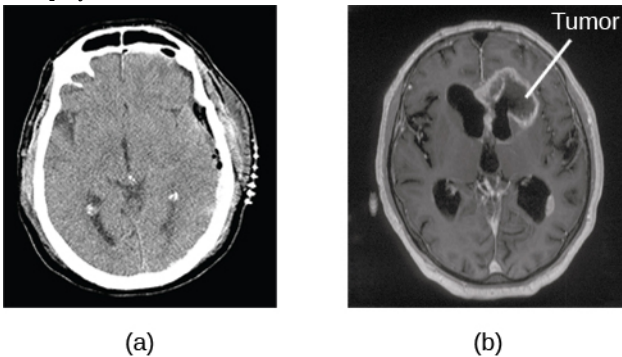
CT scan can be used to show brain tumors. (a) The image on the left shows a healthy brain, whereas (b) the image on the right indicates a brain tumor in the left frontal lobe. (credit a: modification of work by “Aceofhearts1968”/Wikimedia Commons; credit b: modification of work by Roland Schmitt et al)
